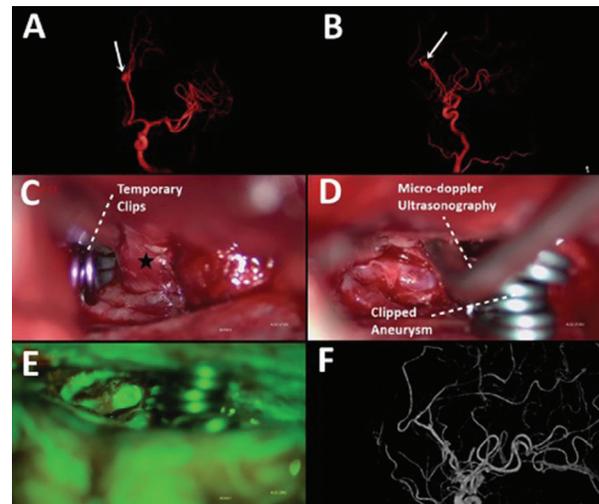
A 55-year-old female patient who underwent surgery due to an aneurysm in the hemorrhaging left pericallosal artery. A,B. Three-dimensional anterior-posterior and lateral images from preoperative digital subtraction angiography (DSA) showing an anterosuperiorly oriented saccular aneurysm with a narrow neck (arrow) in the left pericallosal artery, measuring 6.5×5.2 mm. C. Image of the aneurysm dome (star) and a temporary clip placed proximally to the aneurysm. D. Image of the aneurysm dome being closed with three permanent clips. The distal aneurysm is being explored by micro-Doppler ultrasonography. E. Videoangiography mode image after sodium fluorescein injection showing that the aneurysm dome is not filled. F. Postoperative 3-dimensional DSA image showing millimetric residual aneurysmal filling
